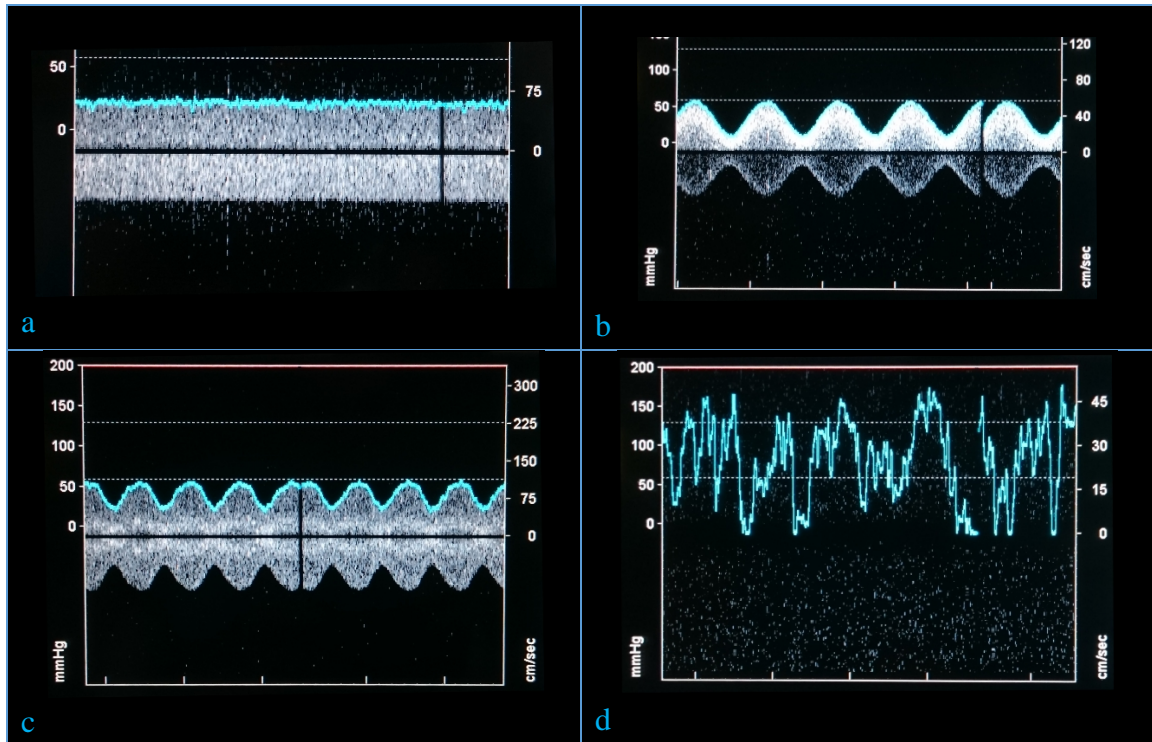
Examples of steady (a), pulsatile (b), patient-specific (c) and ‘turbulent’ Doppler signals. Good quality signals were identified in each case. Only in certain outlet cases at high flow rates was the signal lost as in example (d).
